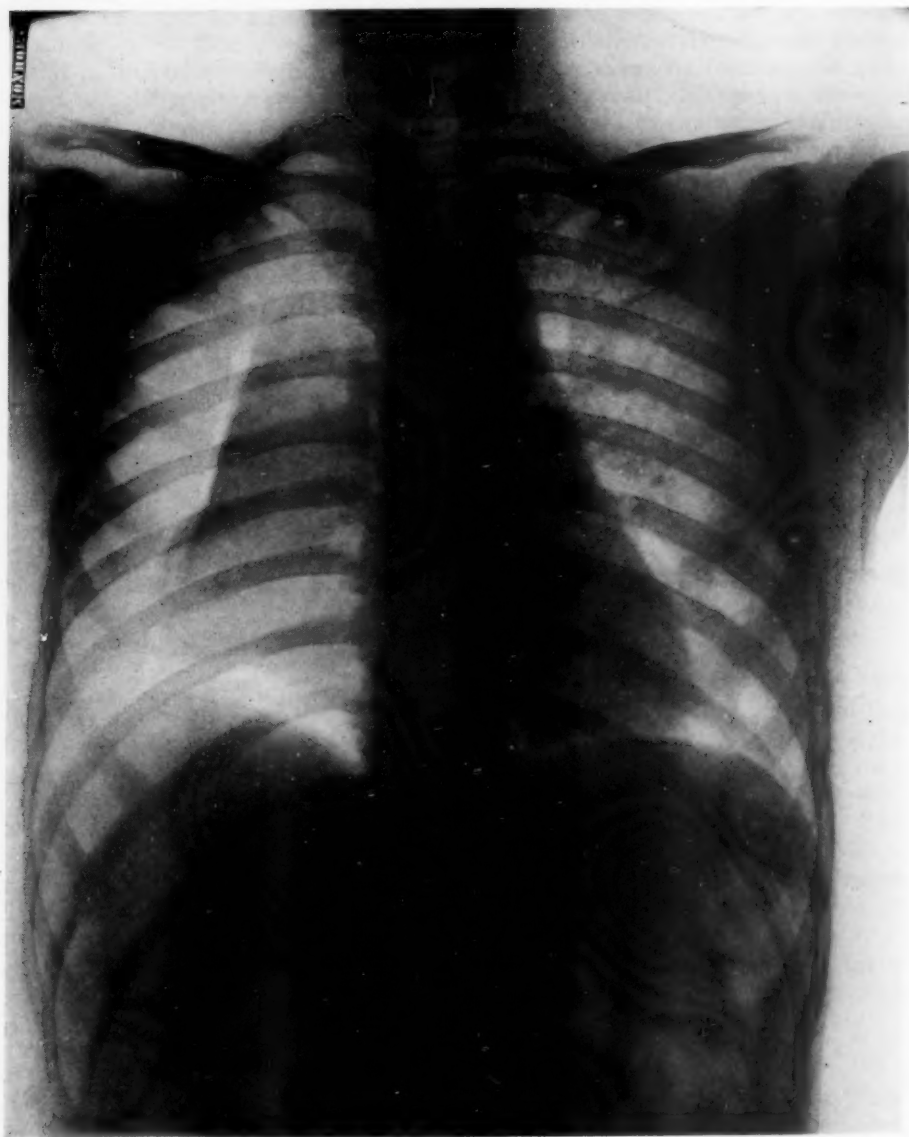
Roentgenogram taken at noon, December 29, after three intrapleural injections of air totalling 900 c.c. The trachea, heart and right diaphragm have resumed their normal position, and there is a good collapse of the involved lung. Temperature  $99.8^{\circ}$  F., pulse 104, respiration 20.
